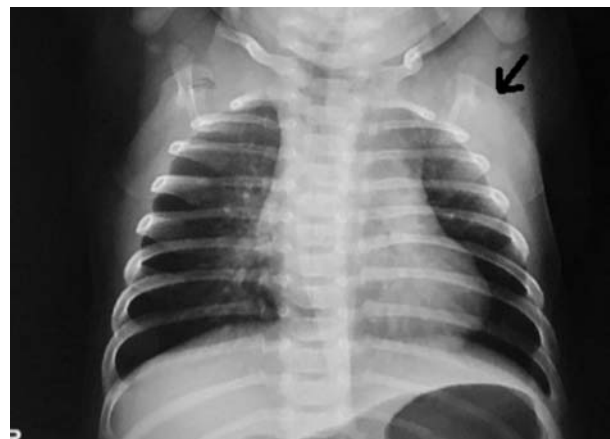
X-ray showing showing thickened and sclerotic left scapula.
